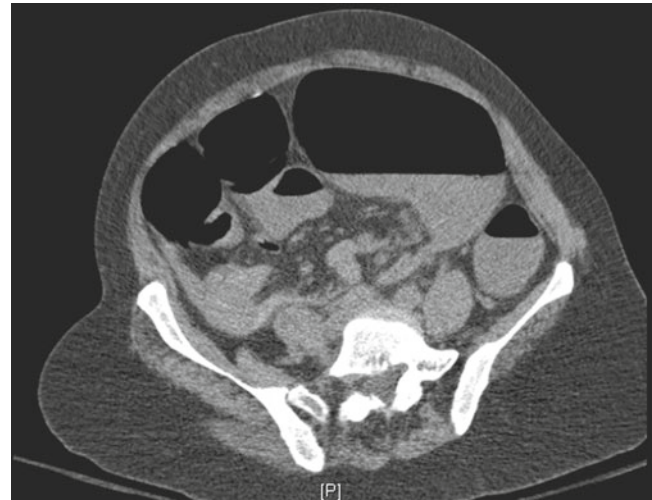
Sigmoid volvulus: CT abdomen and pelvis demonstrates “birds beak” narrowing at the site of the volvulus with proximally dilated colon
